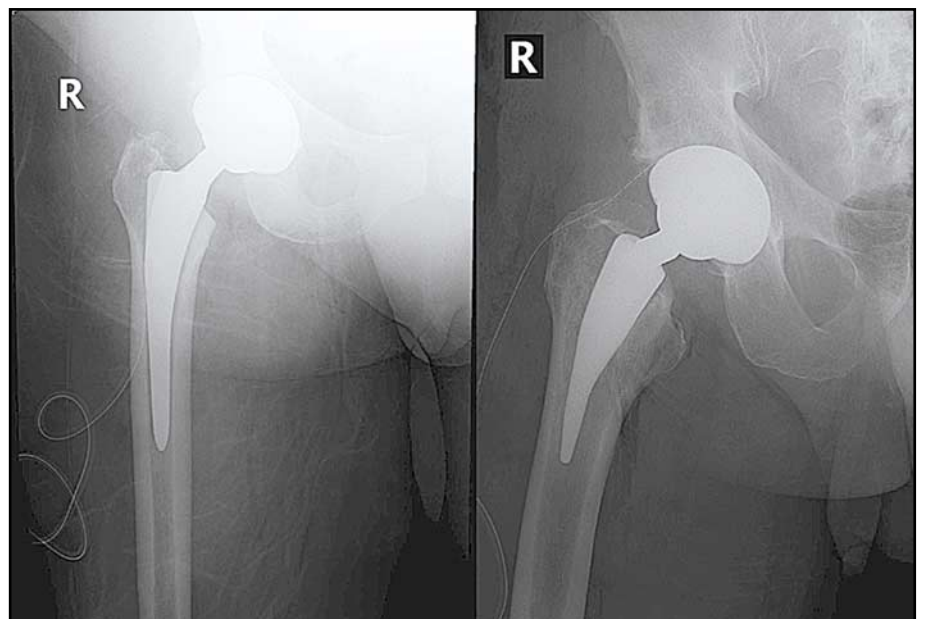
Radiograph of the conventional and short modular femoral stems
